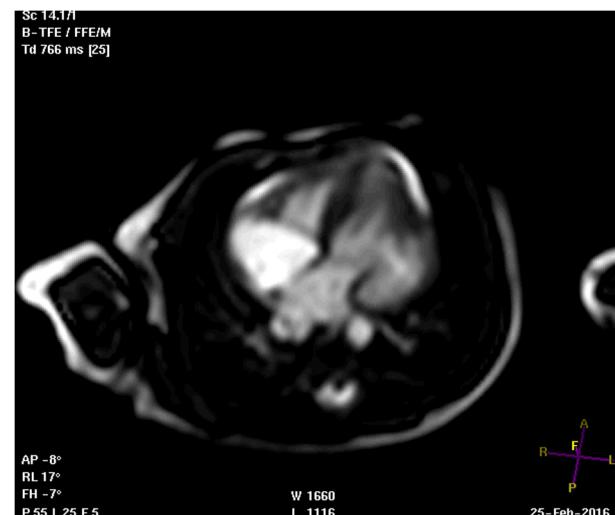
Cardiac MRI showing left ventricular diverticulum.
